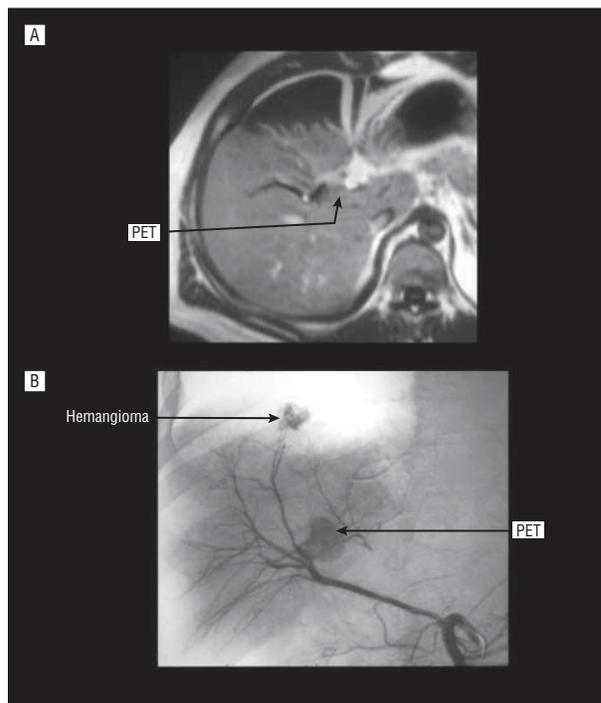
Gadolinium-enhanced magnetic resonance imaging (A) and selective arteriogram (B) of a pancreatic endocrine tumor (PET) that was in the wall of the right hepatic duct. The tumor was abutting the right portal vein. There is a second liver tumor shown on the hepatic arteriogram (B) as a liver hemangioma. The PET was locally resected with the right hepatic duct. The tumor was dissected off the portal vein.
